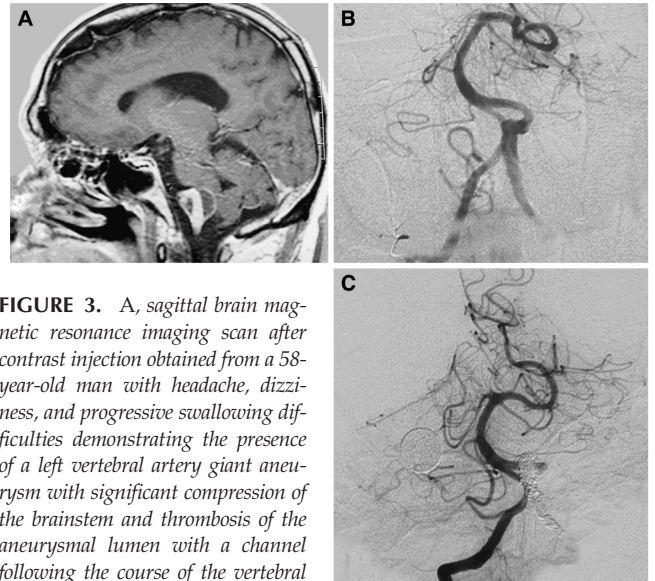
A, sagittal brain magnetic resonance imaging scan after contrast injection obtained from a 58-year-old man with headache, dizziness, and progressive swallowing difficulties demonstrating the presence of a left vertebral artery giant aneurysm with significant compression of the brainstem and thrombosis of the aneurysmal lumen with a channel following the course of the vertebral artery. B, digital subtraction angiogram anteroposterior view of the left vertebral artery injection showing irregularity of the left vertebral artery distal to the takeoff of the posterior inferior cerebellar artery and proximal to the vertebrabasilar junction. The rest of the aneurysmal mass is not visualized secondary to thrombosis. C, digital subtraction angiogram anteroposterior view after GDC embolization and injection of the right vertebral artery demonstrating occlusion of the intraaneurysmal channel with no retrograde flow. The patient had persistent symptoms after trapping, and he underwent surgery for decompression.
